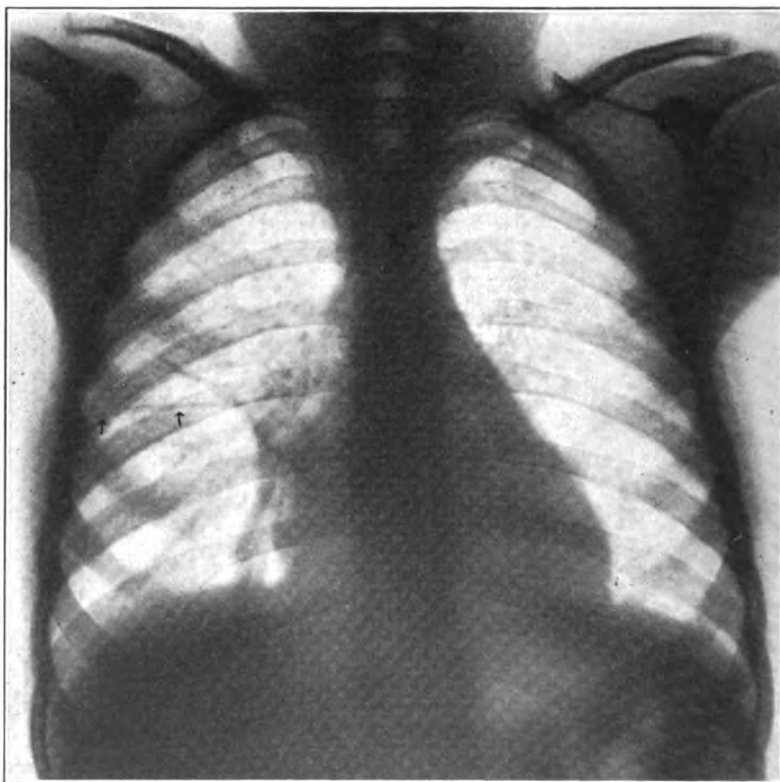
(Case 2). Radiograph taken June 29, 1915. Disappearance of the infiltration present in Figure 5. Note the persistence of the interlobar fissure which is well shown throughout its entire extent.
